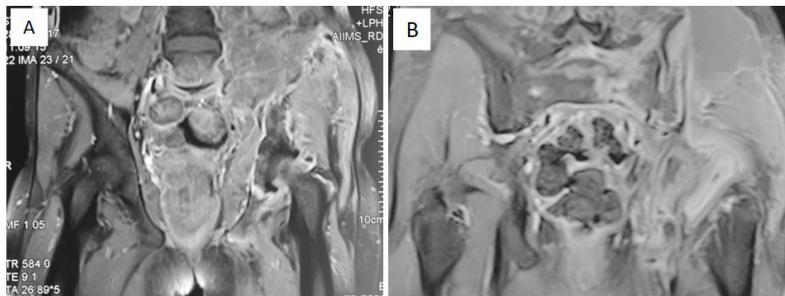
MRI images. Coronal post contrast images at admission (A) and follow-up (B) showing increased bony involvement and left sided collection.
